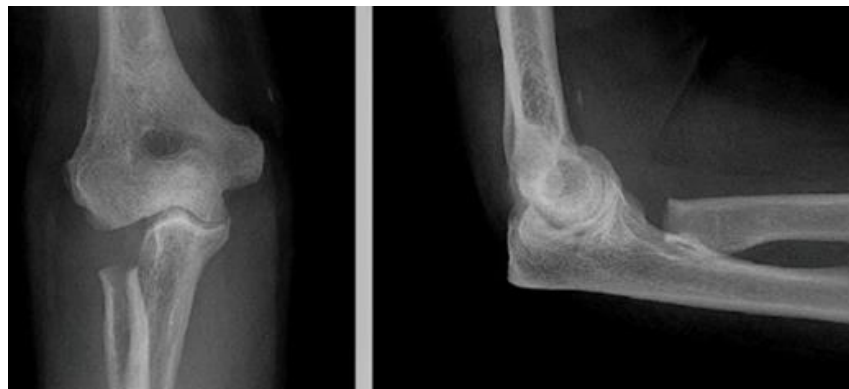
Radiographs at final follow-up of radial head excision
